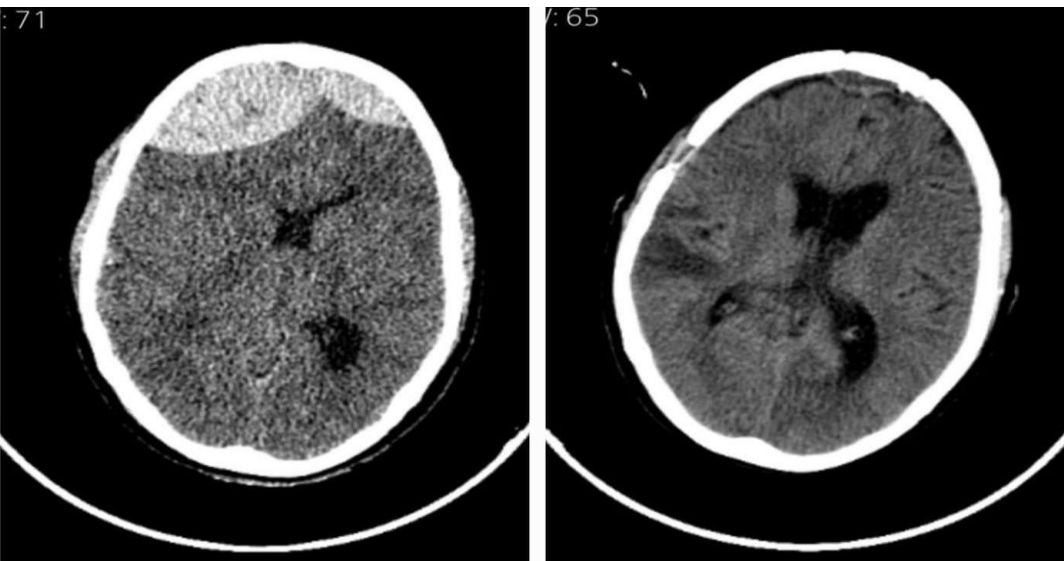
Axial CT Brain shows Bifrontal hematoma.
